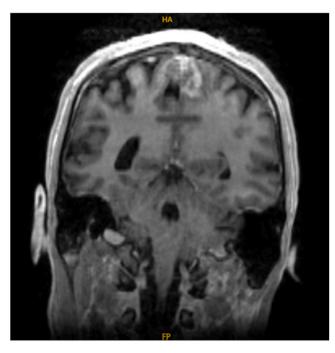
MRI brain showing Cryptococcoma lesion. Coronal postcontrast T1 shows abnormal signal intensity with enhancement in the left pars marginalis.
